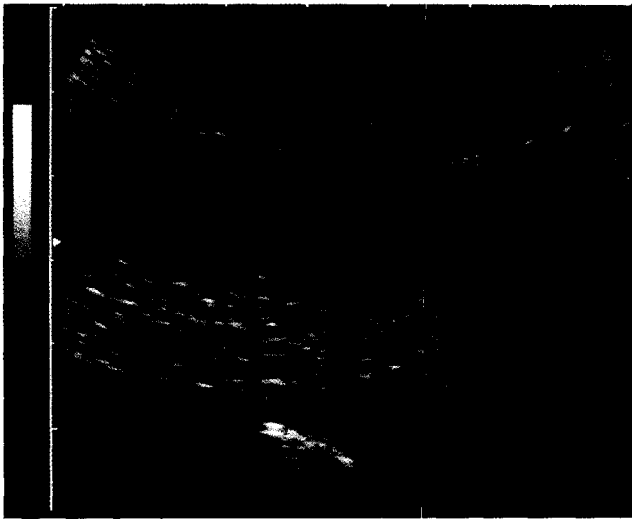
Ultrasound scan of the placenta at 14 weeks of gestation in a partial mole with a euploid fetus (Case 11). The placenta contains diffuse cystic lesions
